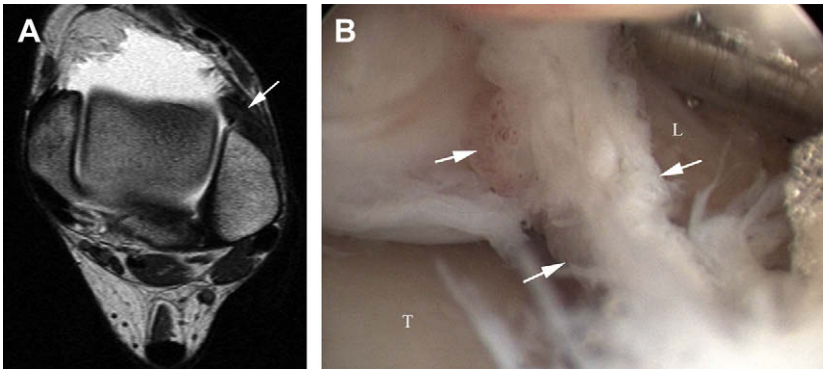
Anterolateral impingement syndrome. (A) Axial T1-weighted spin echo MR arthrography of left ankle shows irregular soft tissue thickening in the anterolateral gutter (arrows). (B) Arthroscopic image demonstrating scarring and synovitis in the anterolateral gutter (arrows). L, lateral malleolus; T, talus.
